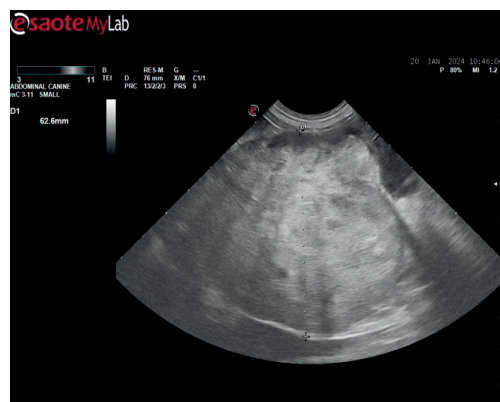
Ultrasound image showing a large, irregular and heterogeneous mass, appearing adherent to the cranial pole of the left kidney and in close contact to the caudal vena cava
